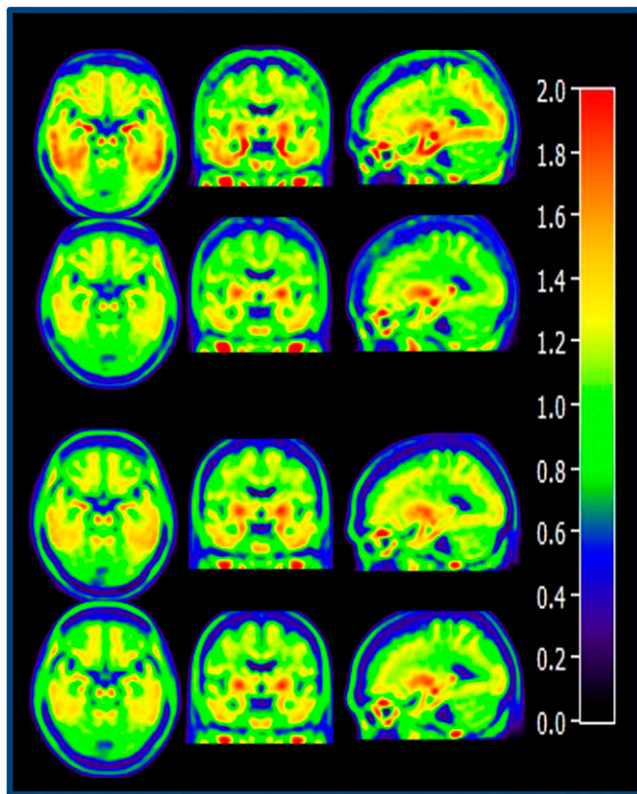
Tau ^{18}F -AV-1451 PET and sex-based modulation of the apolipoprotein E (APOE) $\epsilon 4$ effect in mild cognitive impairment (MCI). The study included both cognitively normal elderly controls and individuals with MCI. Analysis included preprocessed ^{18}F -AV-1451 PET images, T1-weighted structural MR scans, and demographic information. Mean images here show women (top block of 6) and men (bottom block of 6) who were ApoE $\epsilon 4$ carriers (top row in each block) and noncarriers (bottom row in each block). The results suggest that female ApoE $\epsilon 4$ carriers are more susceptible than males to tau accumulation in preclinical Alzheimer disease.
